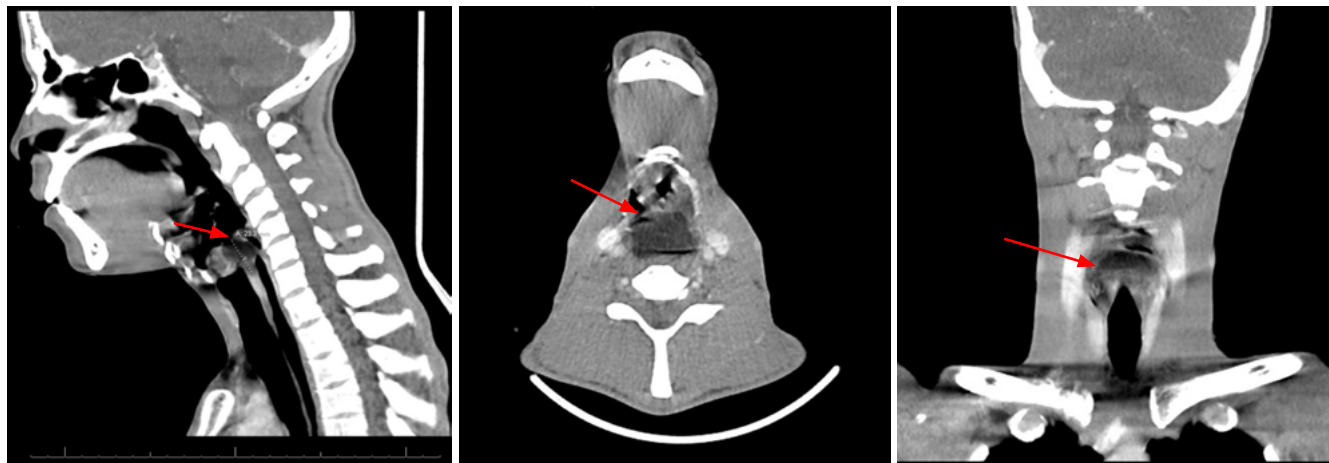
Sagittal, axial and coronal views of CT scan depicting the mass (arrows)
